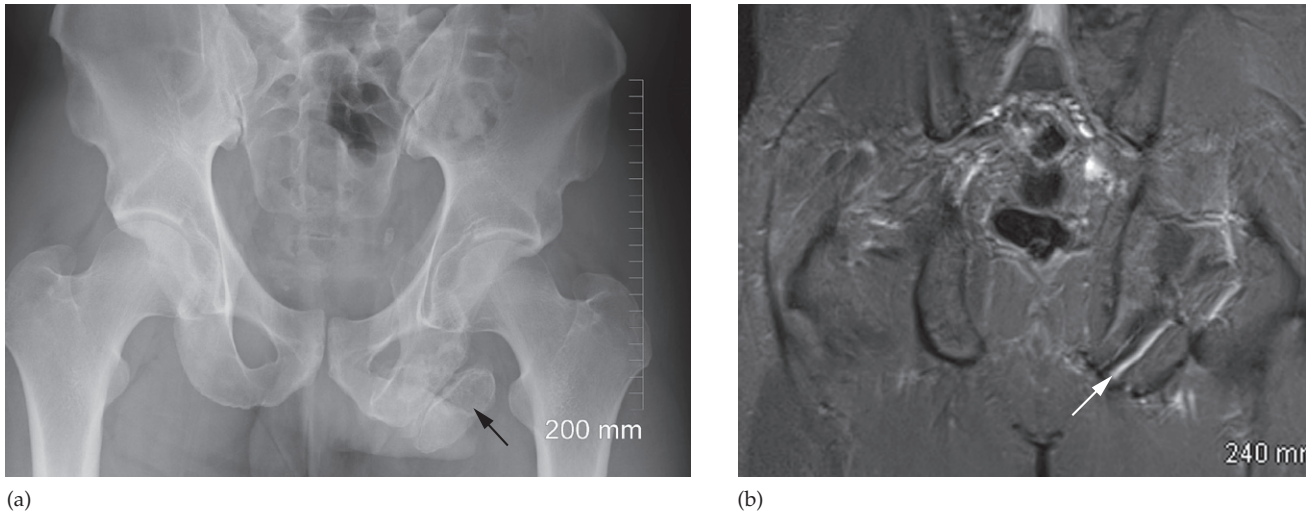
Avulsion fracture. (a) In this example, the avulsed ischial spine appears as a bone fragment adjacent to the ischium (black arrow). (b) MRI showing the non-union of the avulsed fragment (arrow).
